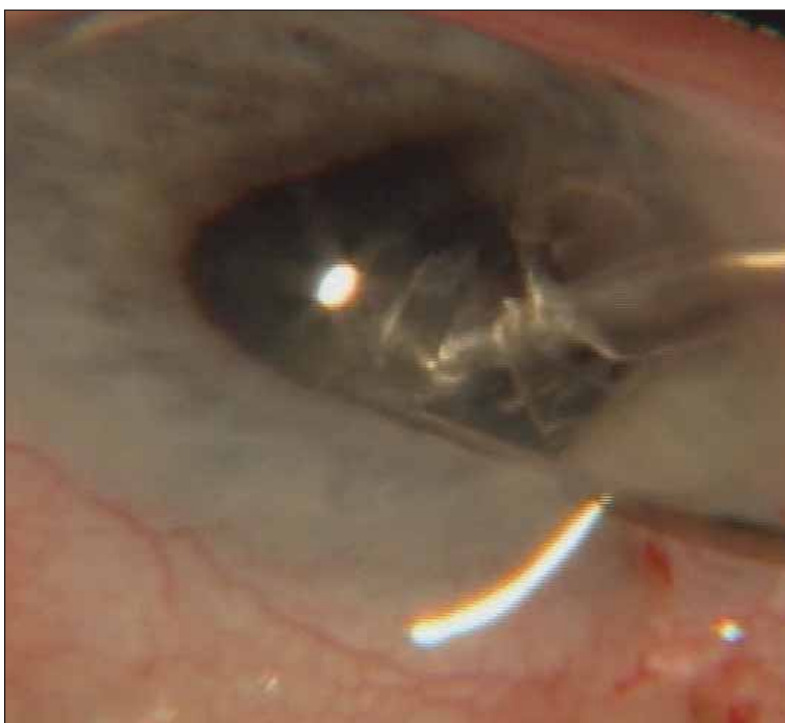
The author demonstrates the followability and safety of using torsional ultrasound in an eye with an iris made floppy by the use of Flomax.
